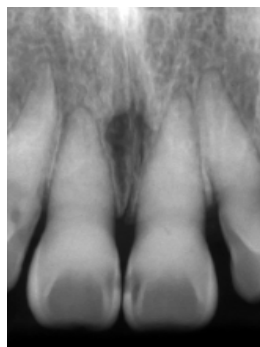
Radiograph at 27 years of age. The dental pulp cavity is almost invisible in 11.
